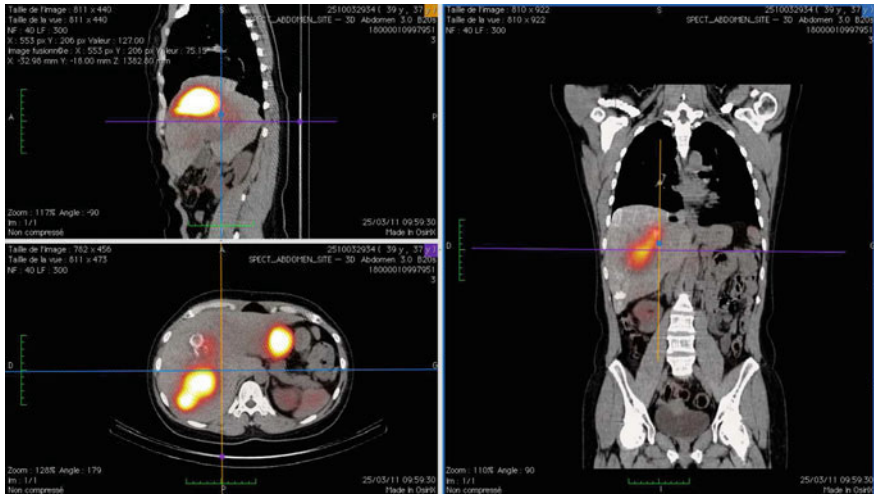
Patient with well-differentiated neuroendocrine tumors: Octreoscan[®] SPECT-CT showed liver metastases
